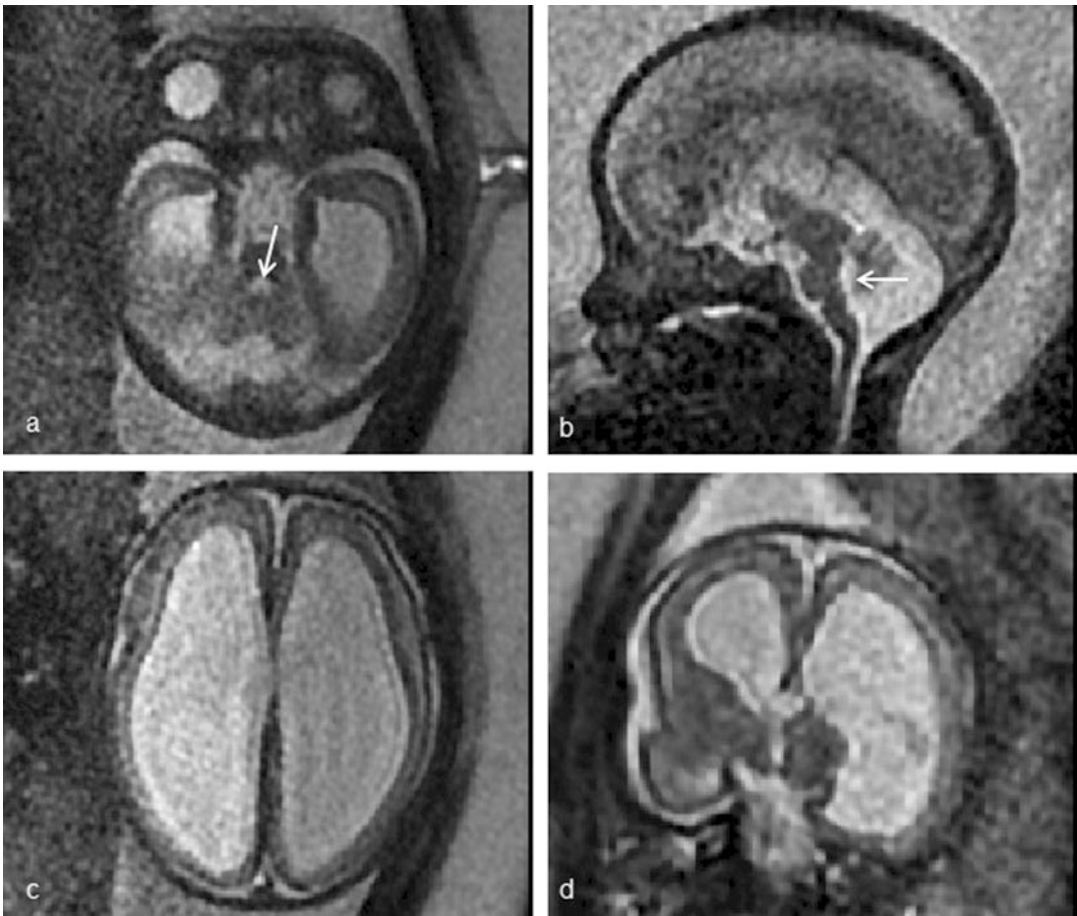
28 week GA MRI with marked hydrocephalus. T2 weighted images in the axial (a, c), sagittal (b), and coronal (d) planes. *White arrows* indicate small fourth ventricle consistent with aqueduct stenosis
